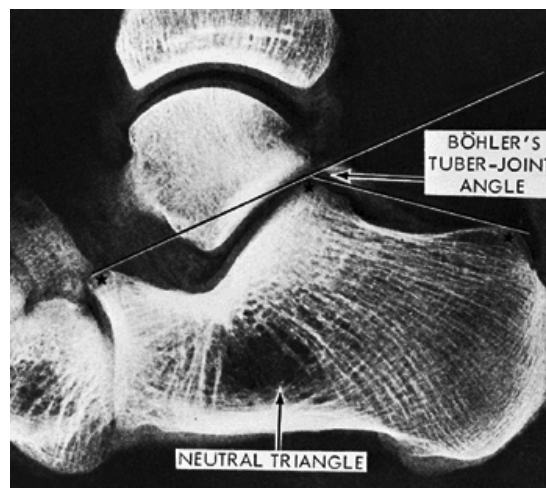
Lateral radiograph shows the neutral triangle (*John et al., 2009*).
